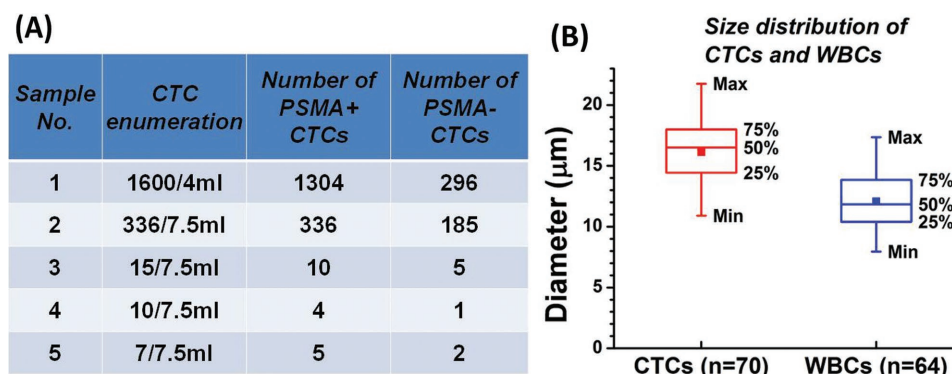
A) The total number of CTCs collected and the PSMA expression of those CTCs from prostate cancer patients. CTCs are defined as nucleated, cytokeratin-positive, CD45-negative cells. B) The size distribution of CTCs and WBCs. The diameters of cells were calculated from images. The data were obtained from 70 CTCs and 64 WBCs all from one patient. The square dot is the average value, whereas the lined box indicates the median value (50%) as well as the 25% and 75% values of the size distribution. The minimum and maximum values are indicated as Min and Max, respectively.
